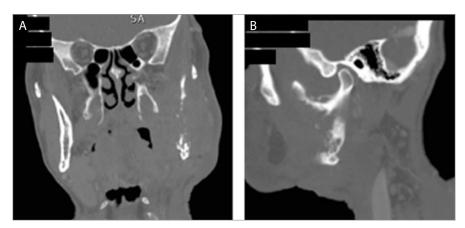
Coronal (A) and sagittal (B) CT images of the same patient.
